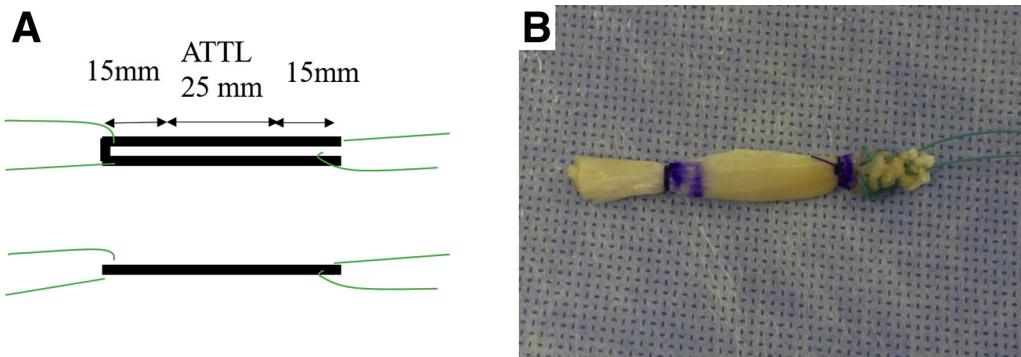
Graft preparation. (A) A hamstring tendon is harvested from the pes anserinus and a 1- to 2-strand graft is prepared. An allograft tendon is an alternative. Required length is estimated on preoperative magnetic resonance imaging and radiographs. Because the ATTL should be at least 25 mm long, the harvested tendon must be longer than 55 mm to contain a 1-strand bundle or 110 mm to contain a 2-strand bundle. The 2 ends form a 15-mm-long bundle or loop to facilitate attachment of the thread for graft delivery. The recommended graft diameter is 4.5 to 5.5 mm. (B) A semitendinosus tendon graft is shown that contains a 1-strand bundle for the ATTL graft. The talar side end of the ATTL graft is sutured using the Krackow method. (Patient 1 is shown.) (ATTL, anterior tibiotalar ligament.)
